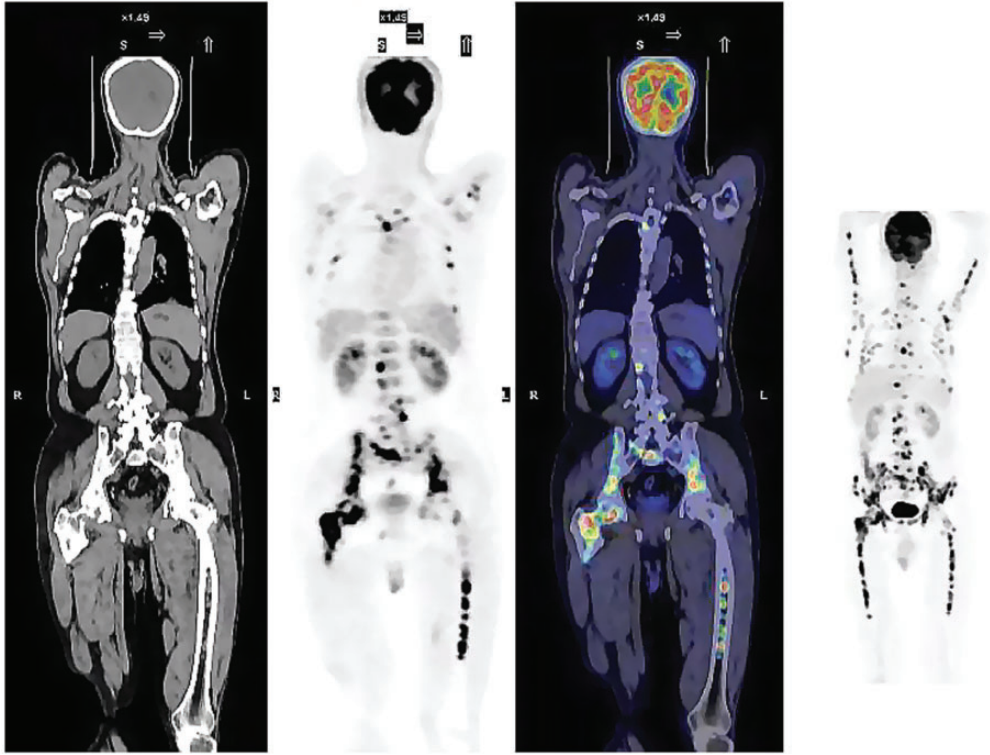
Positron emission tomography-computed tomography of the patient.
